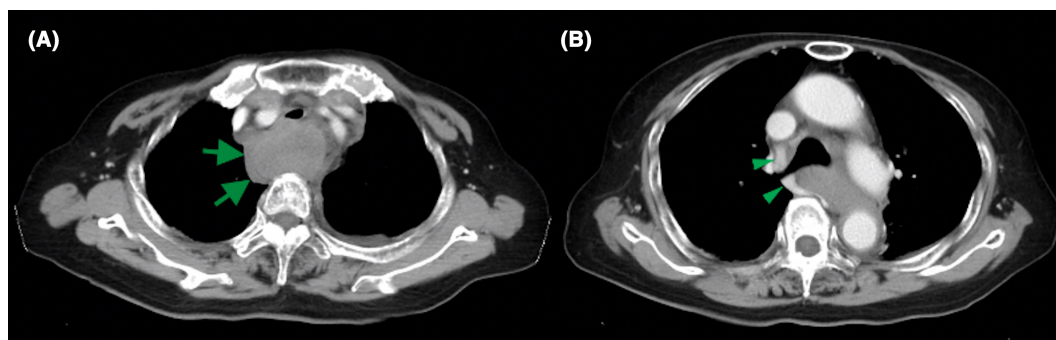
(A) Contrast-enhanced chest computed tomography revealed bilateral pleural effusions and a mediastinal hematoma compressing the trachea and esophagus (arrows). (B) Contrast-enhanced chest computed tomography revealed paratracheal hematoma at the level of the azygos vein (arrowheads).
